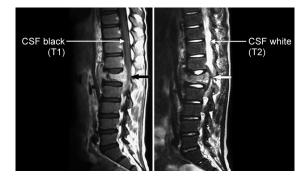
MRI of spine (T₁ and T₂ images)
